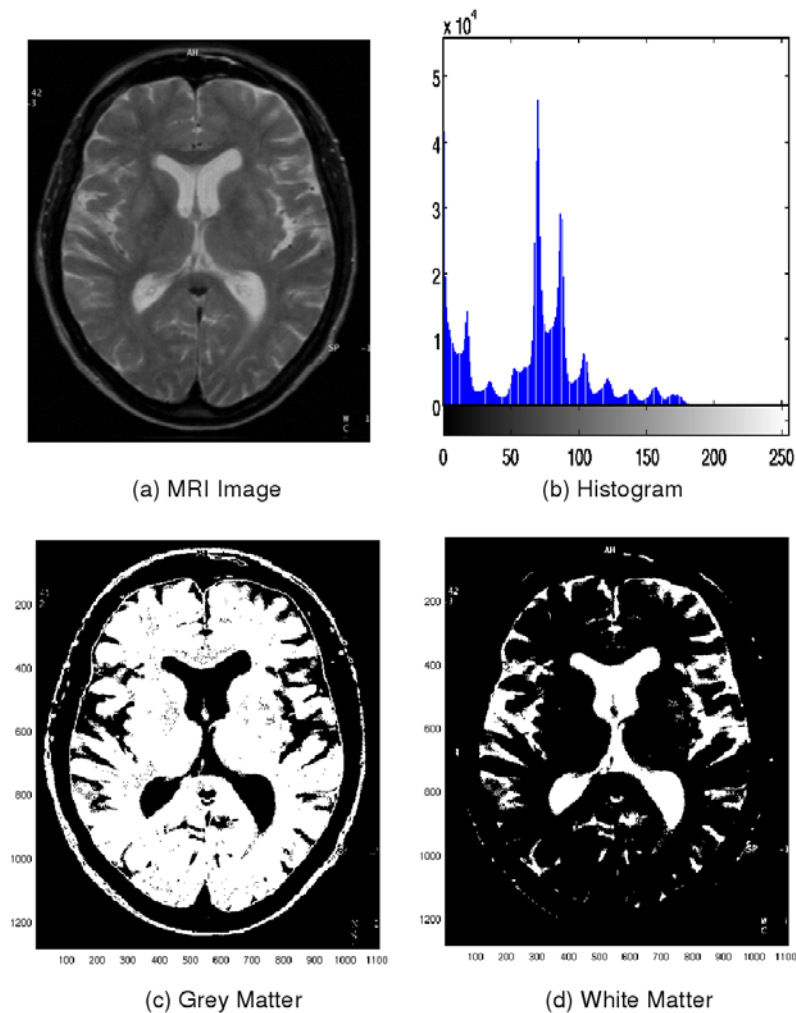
(a) Original MR image (2D), reprinted from Fluri *et al.* (2007) with permission. (b) Histogram of original image. (c) Segment of gray matter by setting intensity range between 50 and 100. (d) Segment of white matter by setting intensity range above 100.
